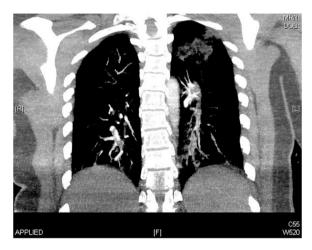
CT-pulmonary angiogram demonstrating bi-lateral pulmonary embolism.
